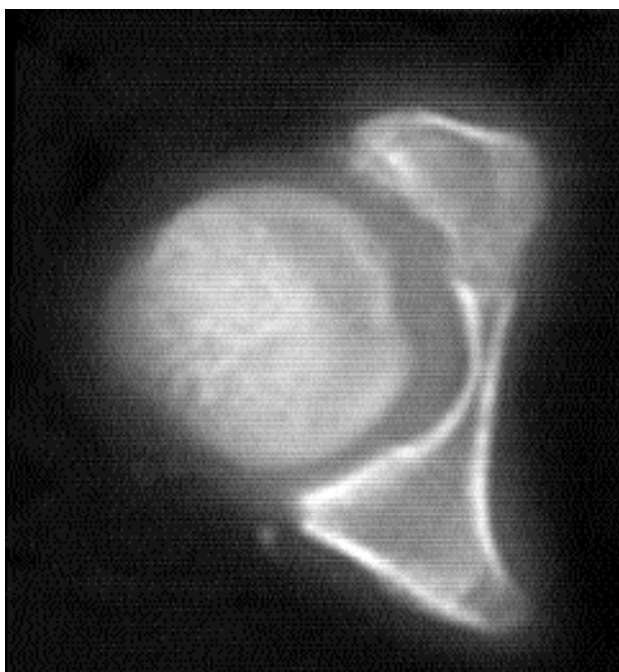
The CT Scan of the patient after closed reduction, with acetabulum posterior wall fracture
